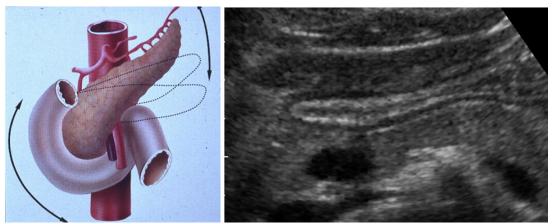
a, b Variability of pancreas tail, gastroduodenal artery and duodenum, and normal sonogram with anterior and posterior antrum wall, as well as optimal imaging of antrum corpus anterior and posterior wall (b); UAS transverse
